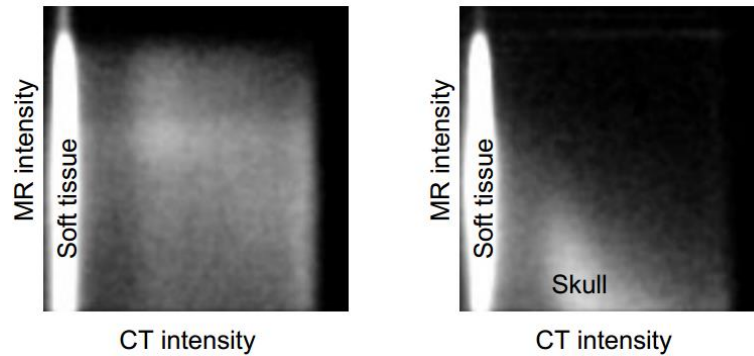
Joint histogram used in a registration problem between a CT and MR example [87].
